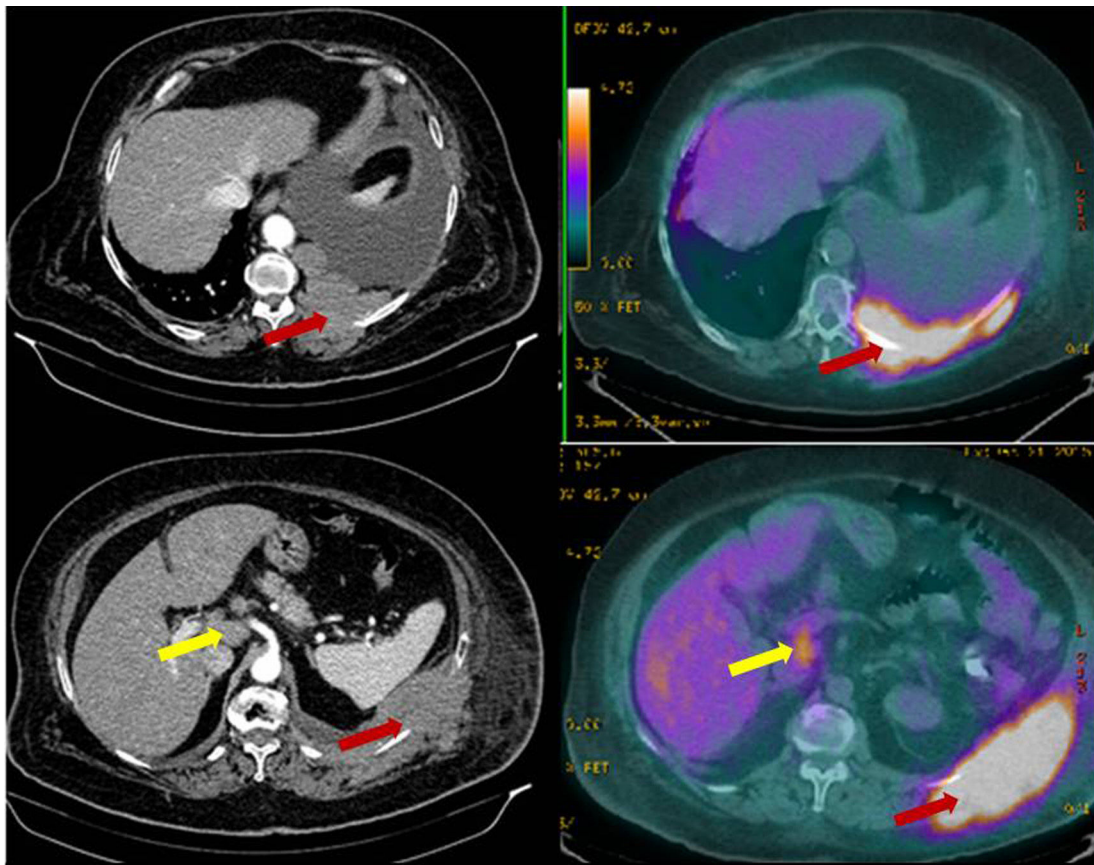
Positron emission tomography: hypermetabolic left pleural mass, with SUV(max) 10.3 consistent with primary neoplastic lesion (black arrows) and abdominal lymphadenopathies in the hepatic hilum, and retropancreatic and para-aortic lymphadenopathies, suggestive of tumor infiltration (white arrows).
